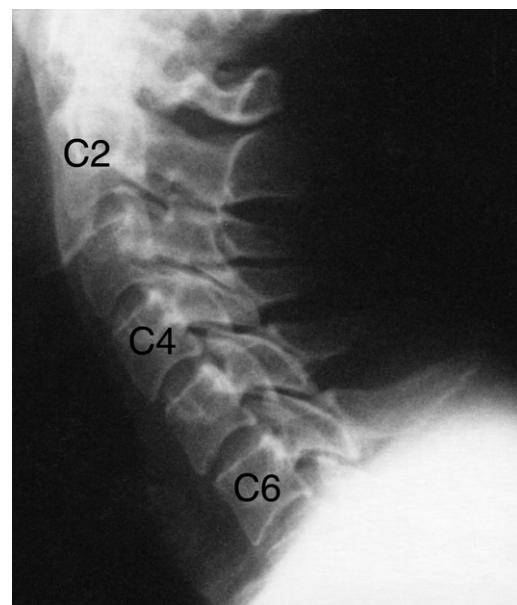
Cervical spine flexion plain X-ray image. Note the marked limitation of range of movement with loss of normal cervical spine contour.
